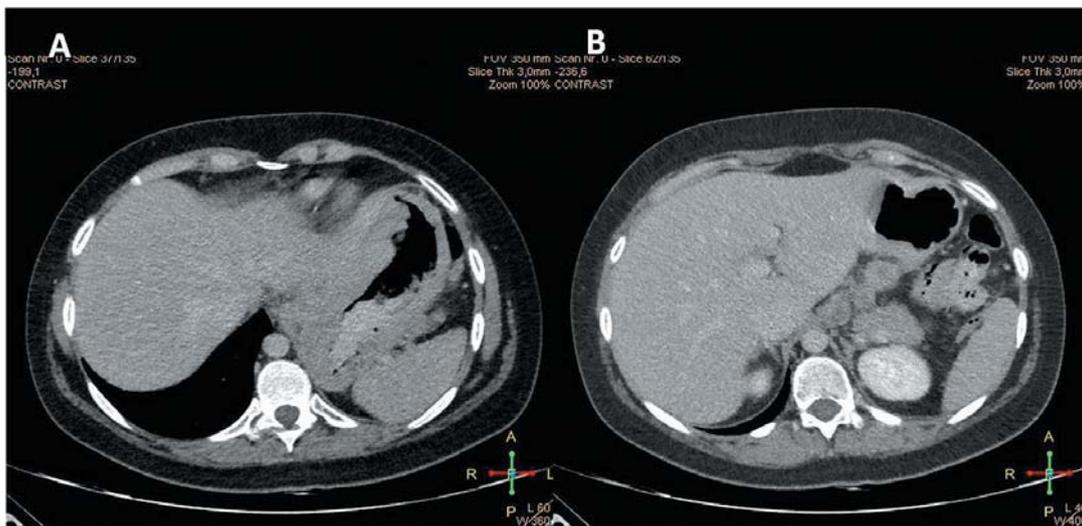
Computed tomographic (CT) scan of case 3 at relapse, showing nodular thickening of the gastric wall (A), and abdominal lymphadenopathy (B).
